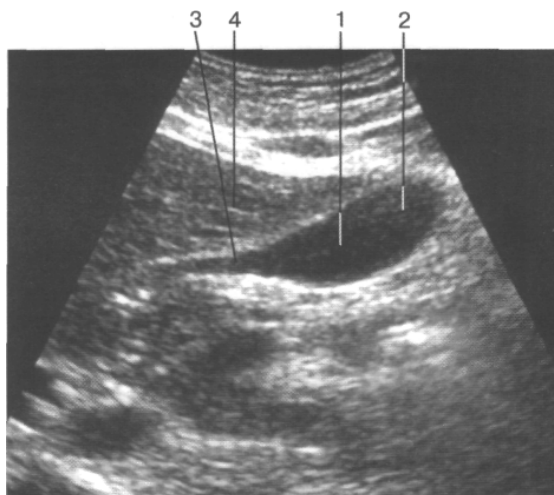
Normal gallbladder ultrasound. The gallbladder appears as organ with anechogenic content: 1– body of gallbladder; 2 – fundus of gallbladder; 3 – neck of gallbladder; 4 – liver [34]
